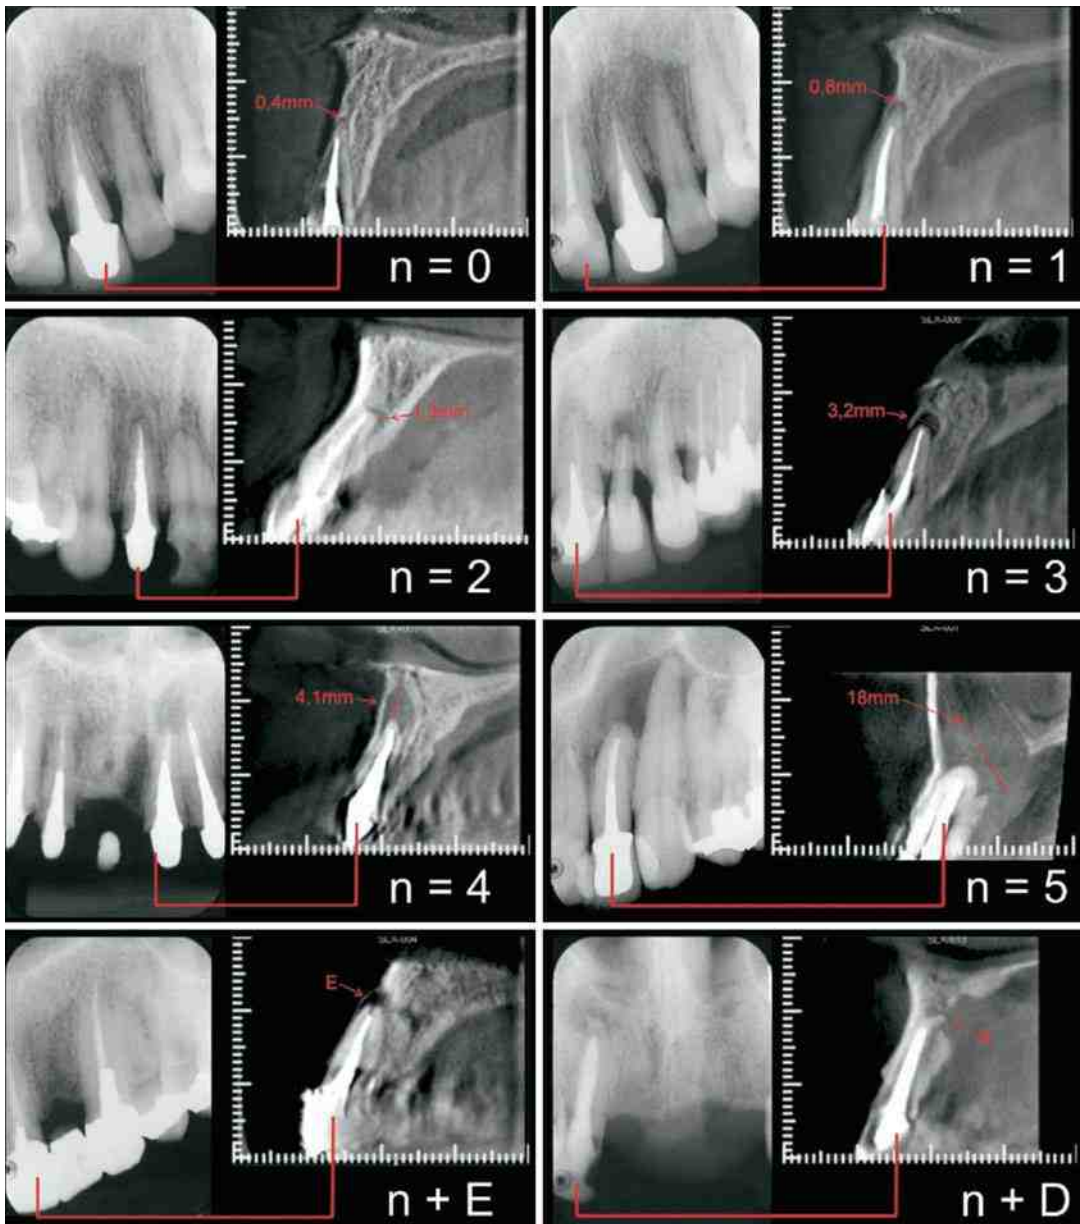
PAI index on CBCT (Reproduced from Estrela and coll)
